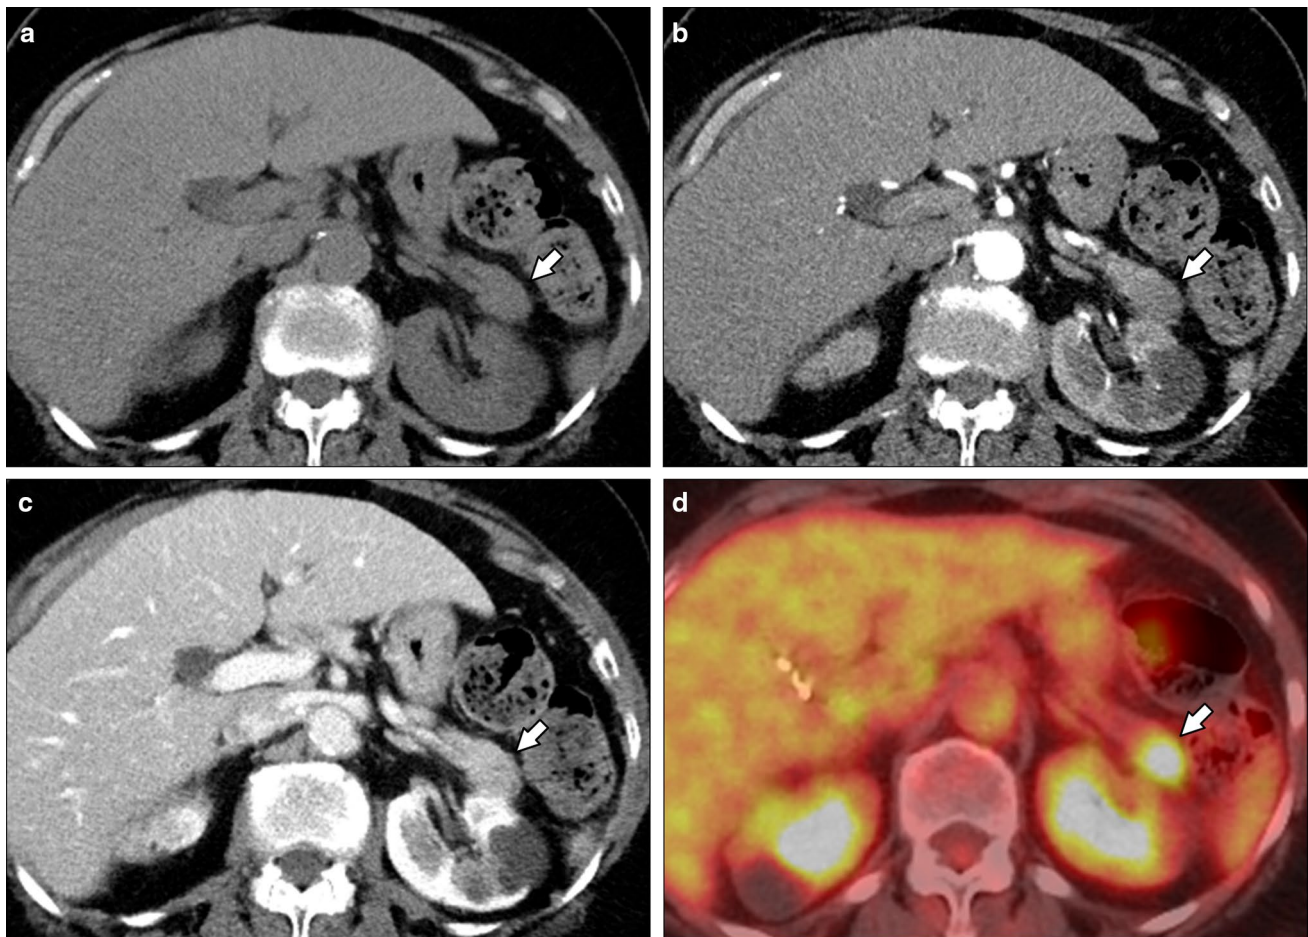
A 79-year-old female with a history of breast and lung cancer with normal serum IgG4 and elevated CA19-9. a Axial unenhanced CT image shows focal enlargement of the pancreatic tail (arrow). b Axial contrast-enhanced arterial and c venous phase CT image shows
